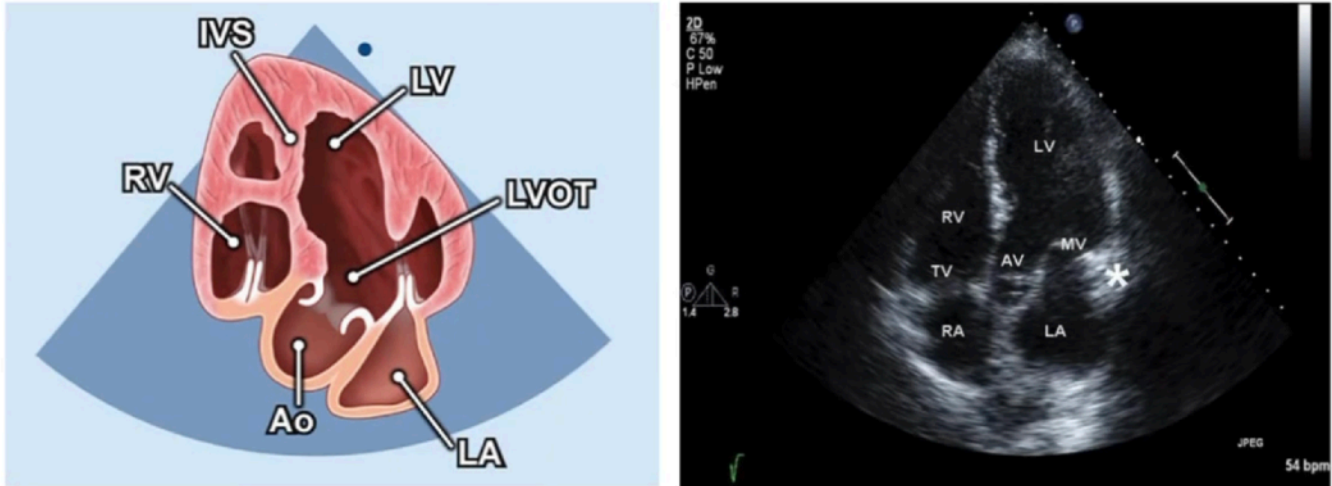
Apical five-chamber echocardiographic demonstrating the LVOT and aortic valve used for Doppler assessment of stroke volume.
